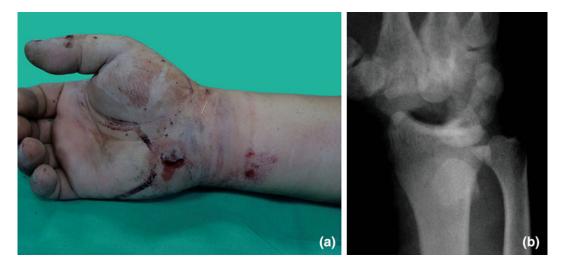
The admitted hand (a); the initial X-rays (b, c); the distraction view (d); volar approach, the volarly dislocated capitate and lunate (e); the proximal scaphoid remained volarly dislocated after the reduction of lunocapitate complex (PS Proximal scaphoid) (f); dorsal approach, absence of bones (H Hamate, DS Distal scaphoid, R Radius) (g); dorsal approach, comminution of the volar radial rim (h); dorsal approach, fracture of the dorsal part of the lunate (asterisk) (i); postoperative X-rays (j, k)
